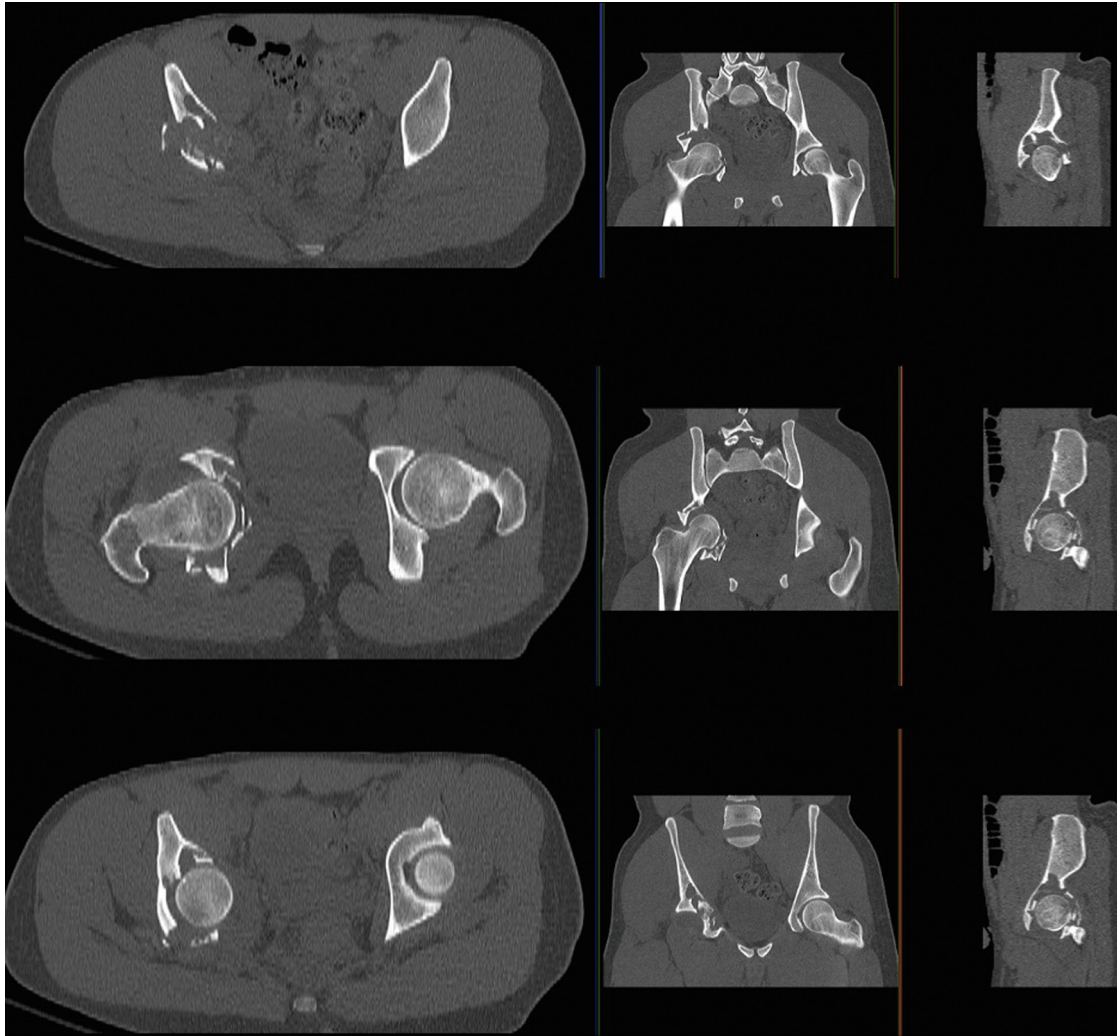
A preoperative computed tomography image demonstrating the lesion, pathologic fracture, and protrusion of the femur.
